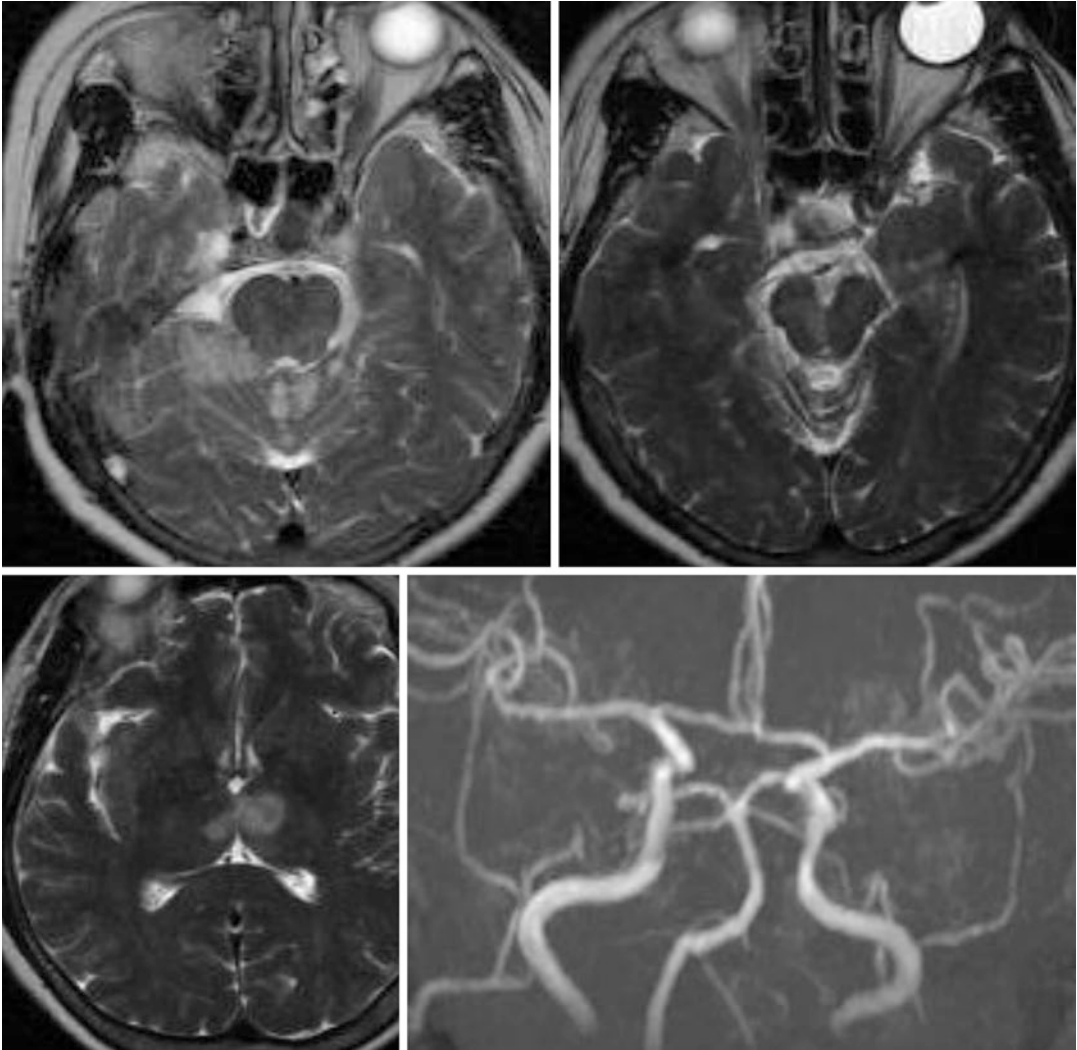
A 75-year-old woman with atrial fibrillation became drowsy and confused. Examination showed confused mentality, somnolence, anterograde memory impairment, vertical gaze failure, and gait ataxia. MRI
